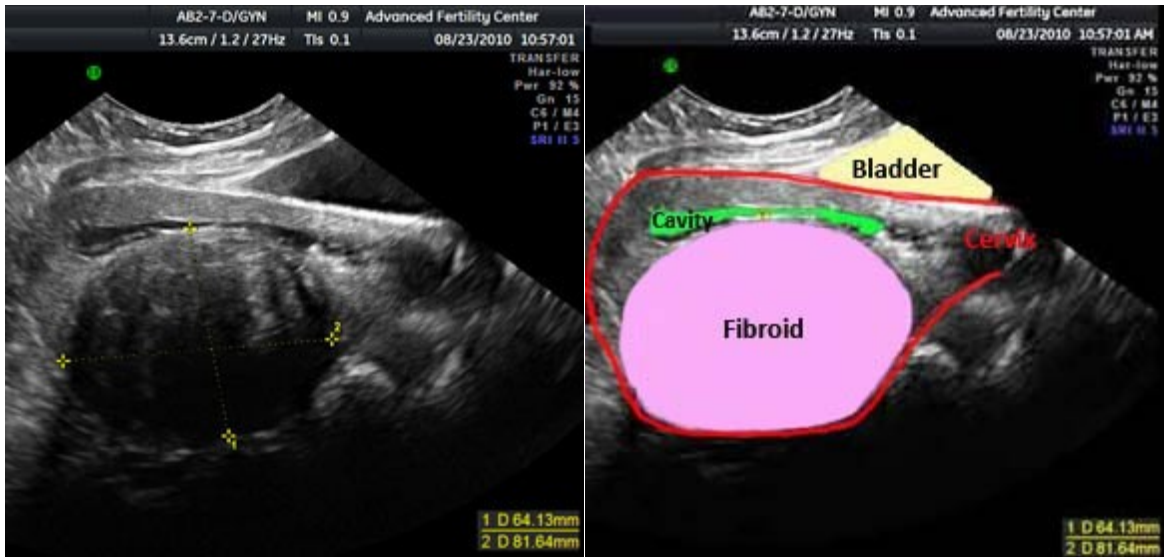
Fibroid - (www.ultrasound-image.com)
